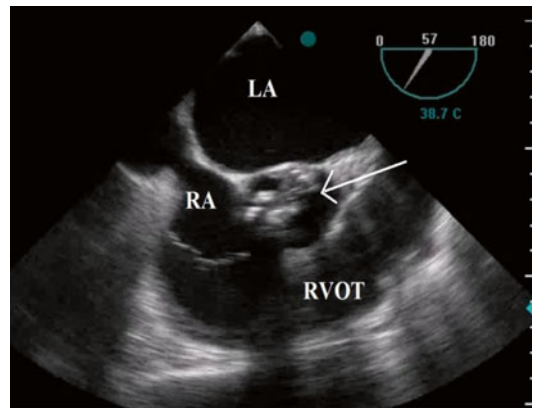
Transesophageal echocardiography showing thickened and calcified BAV in short-axis view (arrow). LA left atrium, RA right atrium, RVOT right ventricular outflow tract (Video 35.2)
